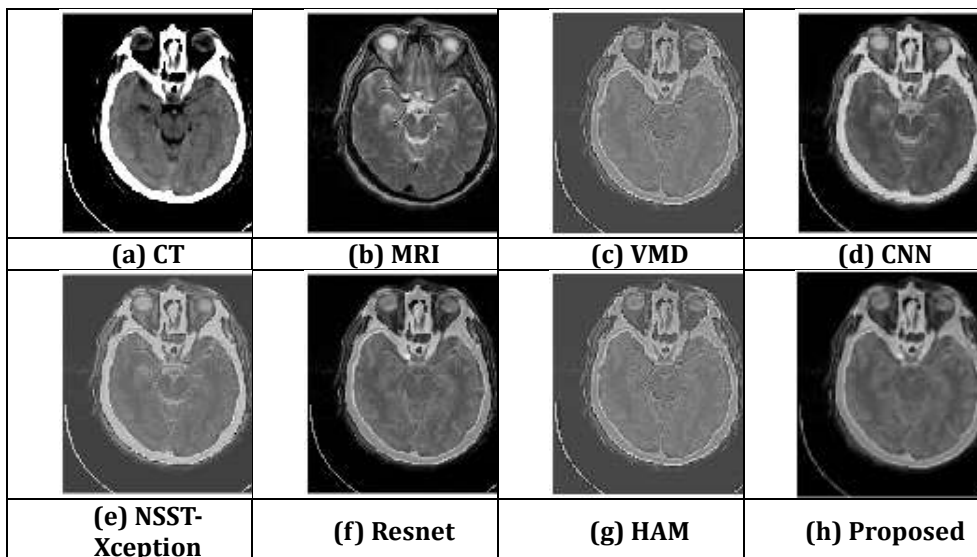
Visual analysis of various methods for CT-MRI-T2 (meningioma)
